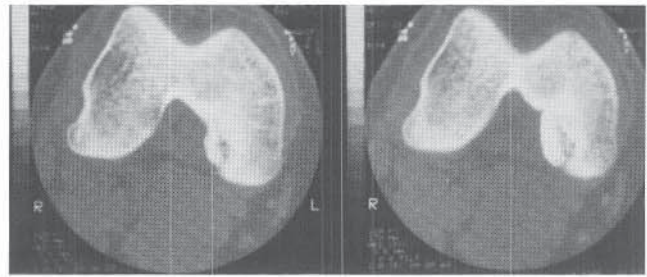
CT scans of the knee showing osteochondritis dissecans of the medial femoral condyle. Note the clear delineation of the extent of the lesion; the fragment is partially detached.
